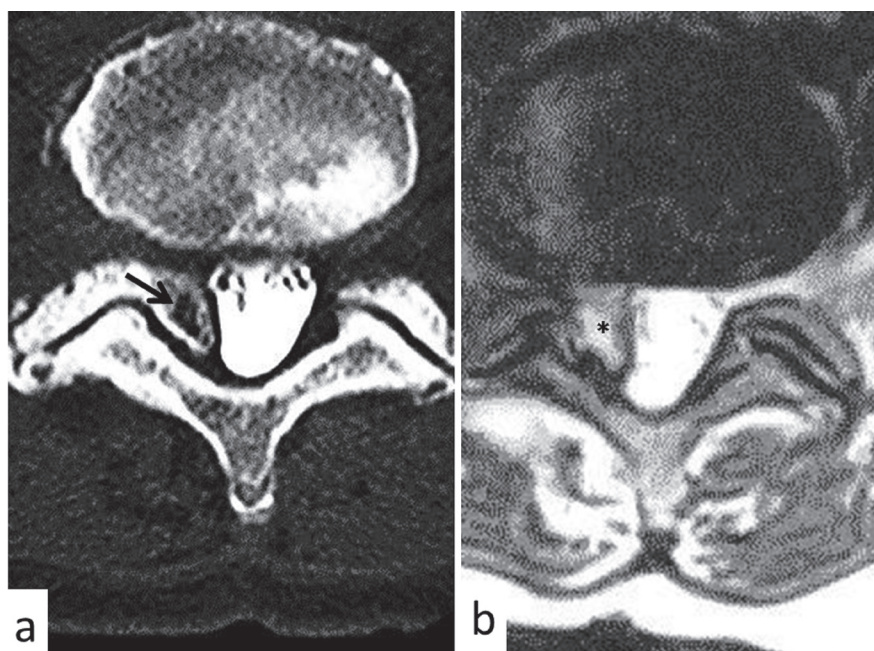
(Patient 2) Computed tomography after myelography showed a bony mass (arrow) with cortical and medullary continuity with superior articular process of the right S1 vertebra (a). Magnetic resonance imaging showed a high intensity cancellous area (asterisk) in T₂-weighted image (b).
